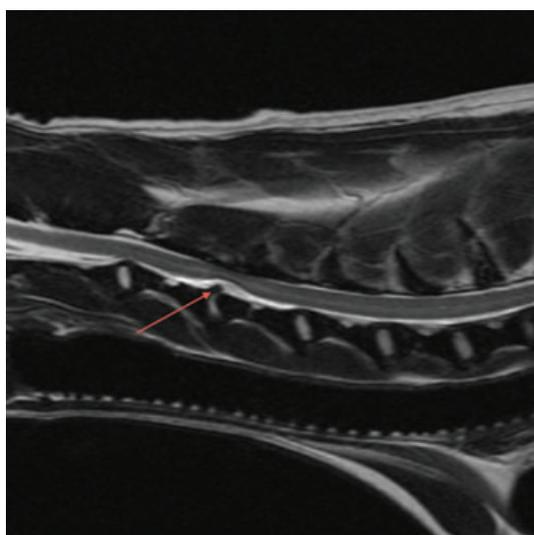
Sagittal T2-weighted image showing suspected extradural compressive material above C3–C4 extending over cranial C4 and isointense to hydrated nucleus pulposus. Ill-defined dorsal annulus (red arrow), reduction in the nuclear volume and narrowing of the affected IVD space are also evident
